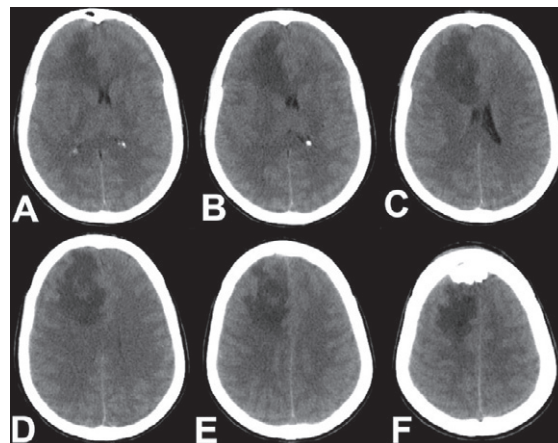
CT scan brain (plain) showing diffuse hypodensity in right frontal lobe mainly involving the white matter (note- the lesion is not confined to any arterial territory)
